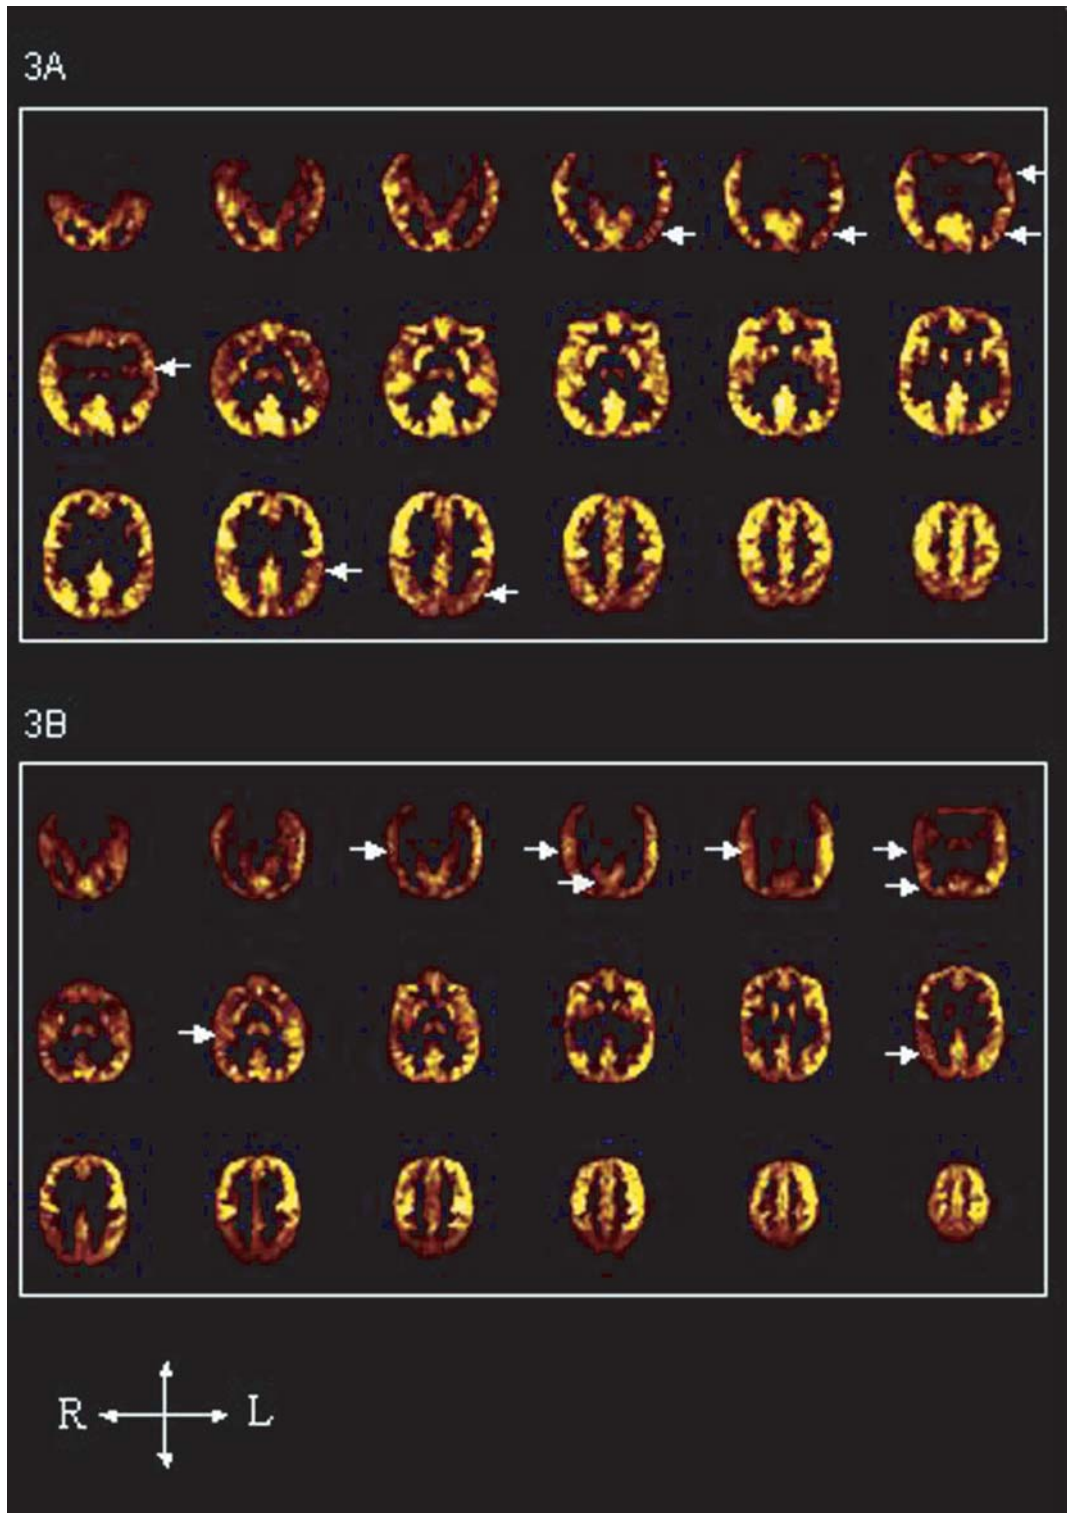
FDG-PET.* A) Patient No 4 demonstrated left, lateral, temporo-occipital hypometabolism, but also left parietal abnormalities; B) Patient No 5 showed an extensive, right hemispheric hypometabolism, involving the lateral temporal cortex, the TPO junction, and the inferior parietal lobule.
